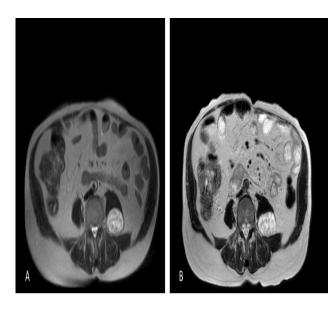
(A and B): First MRI revealing an ovoid, well delimited, 45×30×40 mm, paravertebral and posterior to left psoas muscle mass. Last MRI, 7 years later revealing same dimensions schwannoma.
